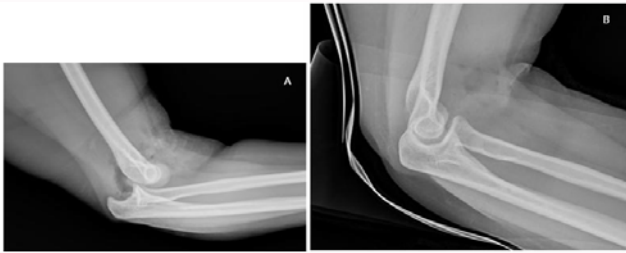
1B: X-ray of the posterior elbow dislocation, before and after closed reduction.
